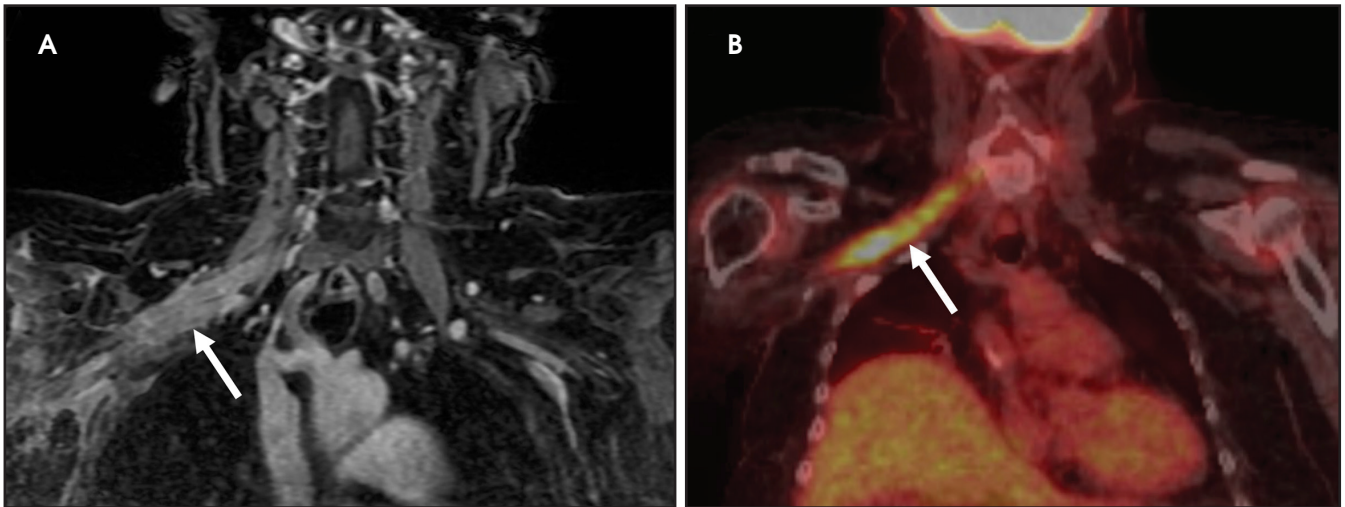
Metastatic versus radiation plexopathy in a 67-year-old woman with metastatic breast carcinoma (known pulmonary metastases). Coronal, contrast-enhanced, T1W, fat-saturated MRI sequence (A). Additional coronal reconstruction from a subsequent FDG-PET/CT (B). There is extensive contrast-enhancement of the right brachial plexus, extending from the trunks to the axillary region (solid arrow). Prior scans had shown less marked aggregation and enhancement, likely in favor of post-radiotherapy plexopathy (images not shown). Due to the interval progression, metastatic disease was a key consideration and an FDG-PET/CT confirmed the presence of avid FDG uptake along the brachial plexus (solid arrow). This was highly suspicious for metastatic disease and a biopsy was confirmatory. In equivocal cases, FDG-PET/CT is a useful tool to distinguish radiation versus metastatic plexopathy.
